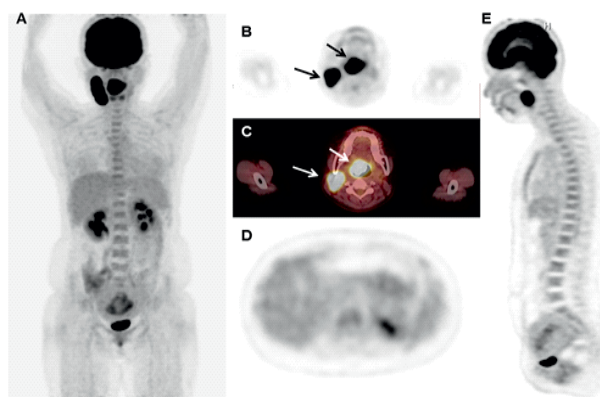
Maximum intensity projection (A), transaxial (B) and (D), and sagittal (E) ^{18}F -FDG PET images and transaxial fused PET/CT images (C), of a 28 year old woman with diffuse large B-cell lymphoma. Lymphoma involvement is seen in the right palatine tonsil and right neck area with Lmax of 39.18 (arrows in (B) and (C)). No other region showed lymphoma involvement on ^{18}F -FDG PET/CT with negative result on BM biopsy. Diffusely increased ^{18}F -FDG uptake of BM is shown with BM SUV of 1.82 and BLR of 0.95. Serum CRP level, NLR, and PLR were 23.82mg/dL, 3.84, and 166.10, respectively. The patient underwent chemotherapy that consisted of doxorubicin, cyclophosphamide, vincristine, and prednisone with rituximab, achieving complete response after 6 cycles of chemotherapy. However, lymphoma was recurred 13.4 months after the treatment.
